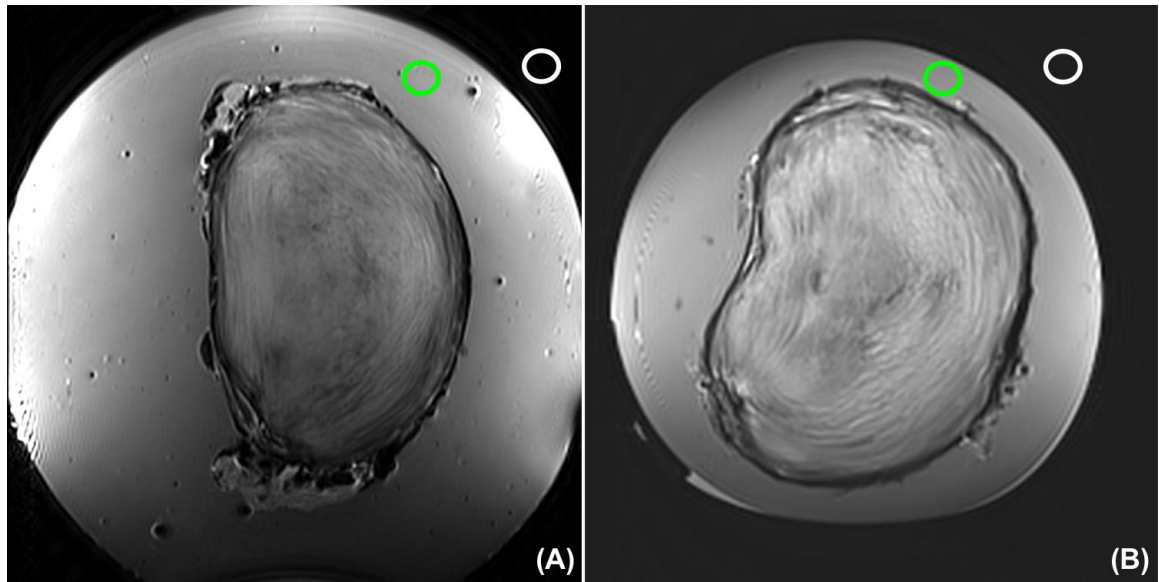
However, this apparent decrease in SNR still left a 20:1 ratio and strong lamellar contrast. Additionally, the loading frame was able to maintain disc hydration and hold an applied displacement throughout experimentation. The applied 5% axial strain, which was calculated from initial MRI mid-sagittal/coronal disc height measurements, achieved a successful average E_{zz} of $-4.88 \pm 0.33\%$. The tight integration of the loading frame with MRI and RF coil enabled reliable positioning of the disc between scans, minimizing rigid body motion between image sets. The developed loading frame will be utilized in [Chapter 7-8] to apply incremental amounts of axial compression.
